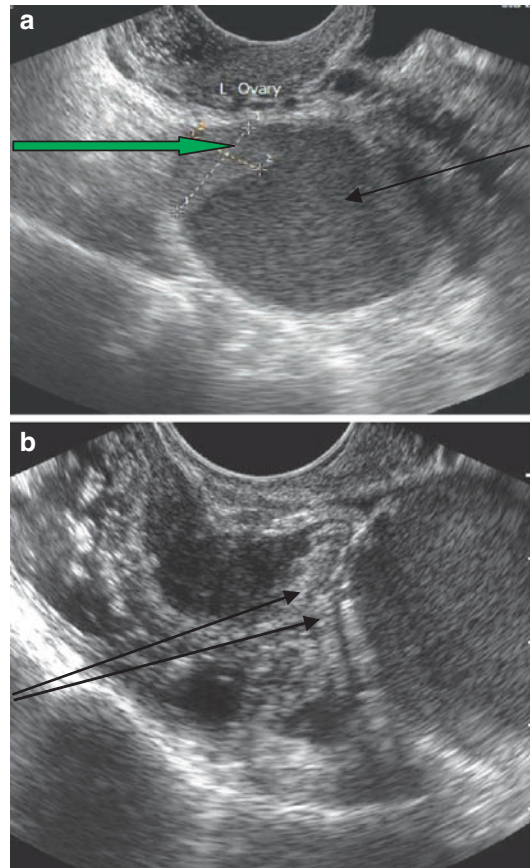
(a) Transperineal ultrasound showing an endometriotic ovarian cyst (arrow) showing a solid component (block arrow) thought to be secondary to bleeding, (b) trans-perineal ultrasound showing rectal wall infiltration by endometriosis (arrow).
